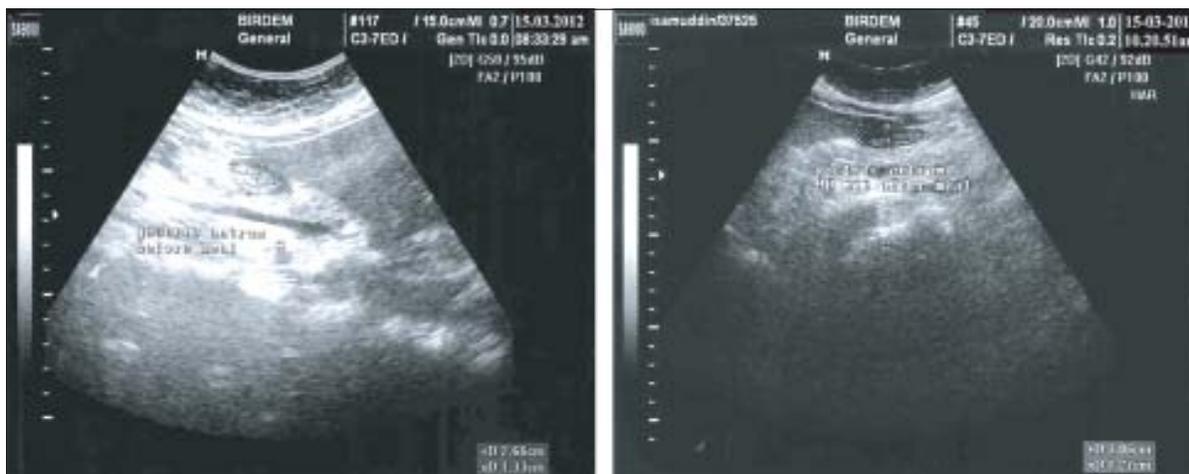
Sonographic Image of gastric antrum of healthy subject before meal and 90 minutes after breakfast
